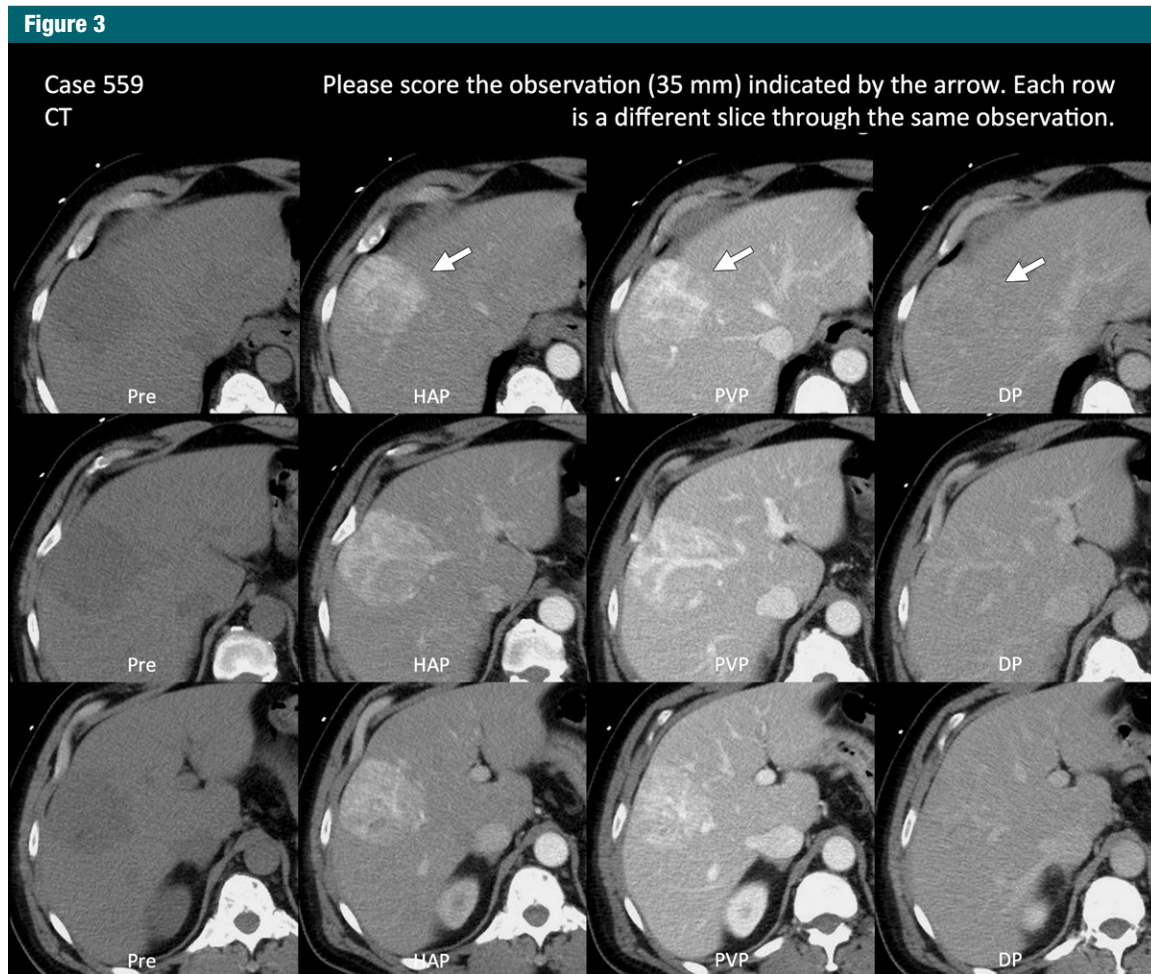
CT image set with low agreement. The image set is exactly as it was presented to reviewers. Consensus reading by the steering committee was LR-M. The most frequent category assigned by reviewers was LR-5, assigned by approximately 33% of reviewers. This image set is a challenging example, and the lesion (arrows) could arguably be categorized as LR-4. *DP* = delayed phase *HAP* = hepatic arterial phase, *Pre* = precontrast, *PVP* = portal venous phase.
